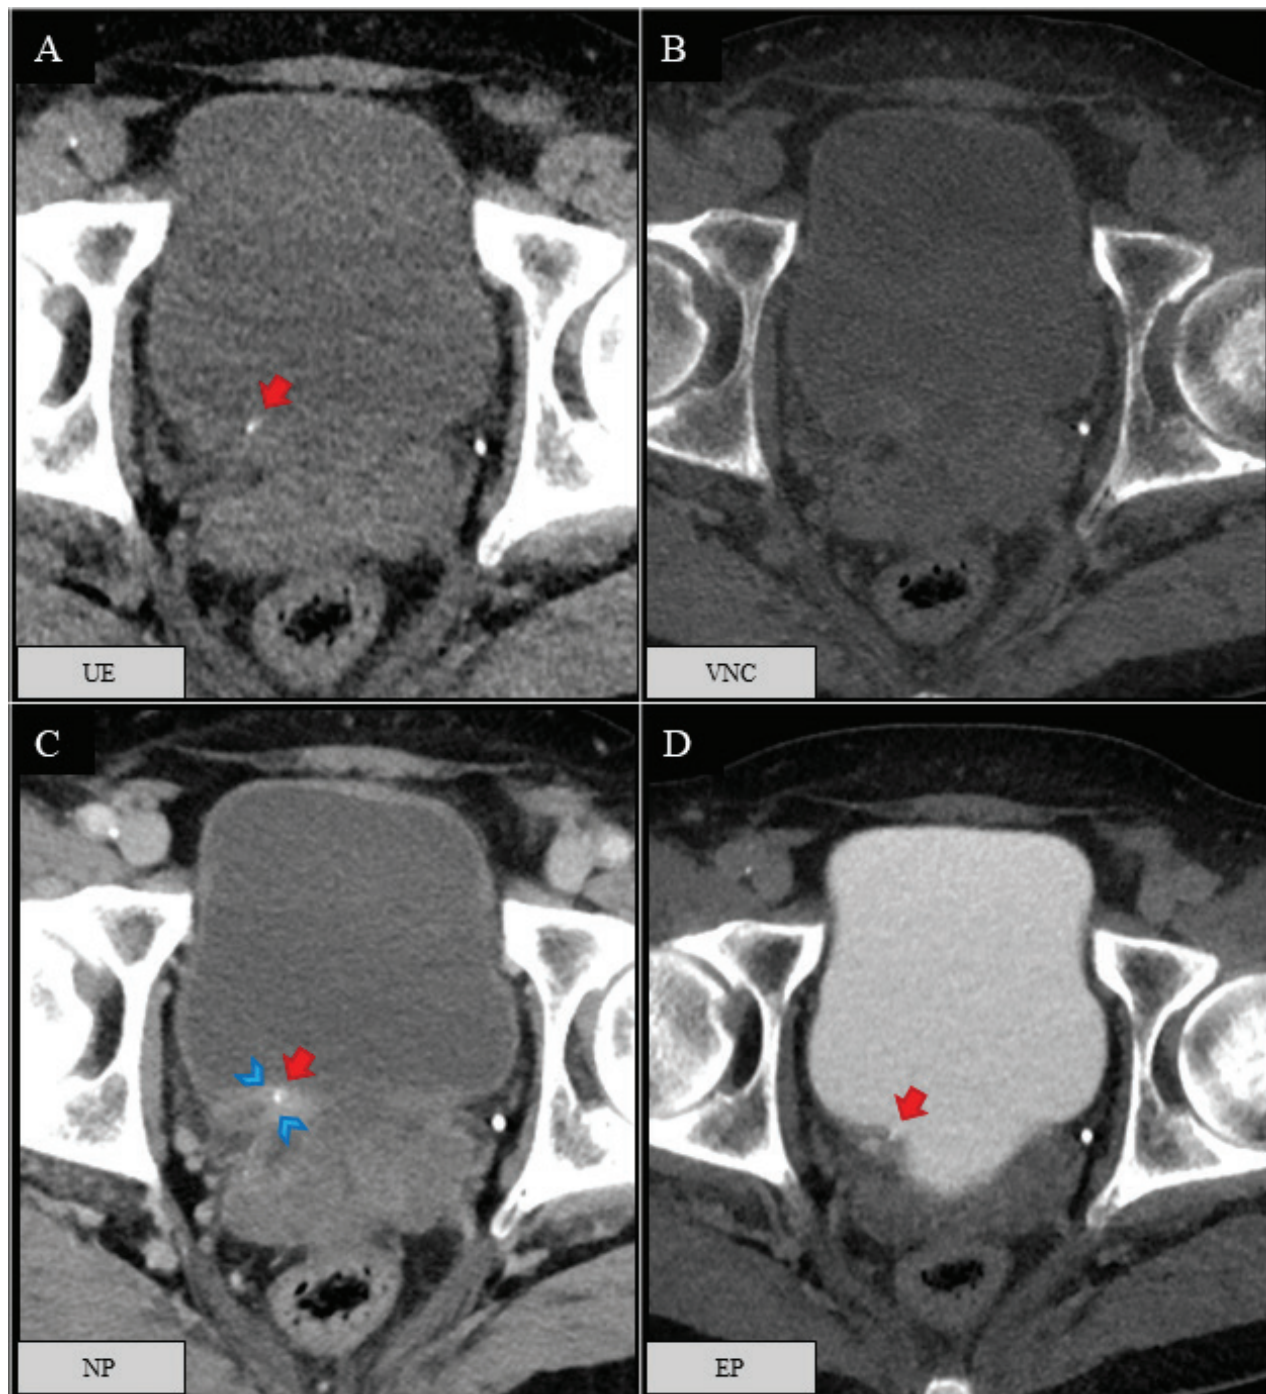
(A–D) A 56-year-old male with a stone (red arrow) close to the ostium in the right ureter. The experimental CT was scored positive for ureteral stone by both readers. The stone was invisible on axial VNC (B). The urothelium was contrast enhancing and thickened (blue arrowheads) on axial NP (C) as a sign of obstruction in the ureter. However, with no clinical signs of renal failure or sepsis, the patient received no immediate active stone treatment. A 3-month follow-up CT showed that the stone had passed spontaneously.
